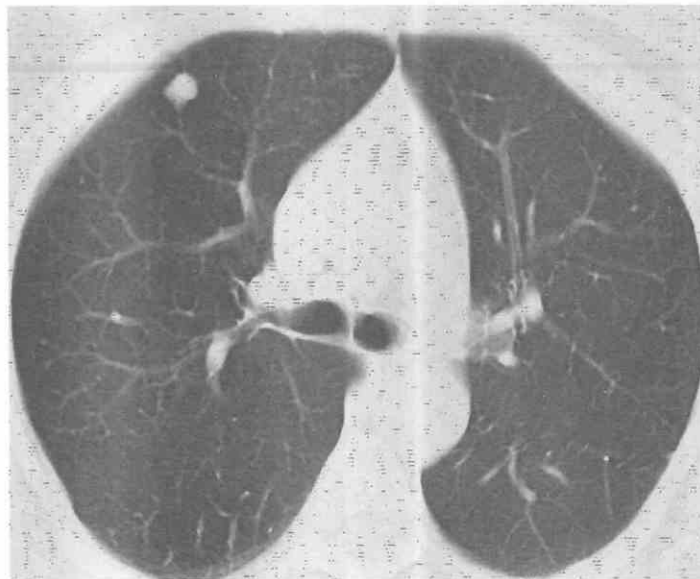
Typical carcinoid seen as a solitary peripheral nodule. CT shows a well-circumscribed small nodule in the right upper lobe.
